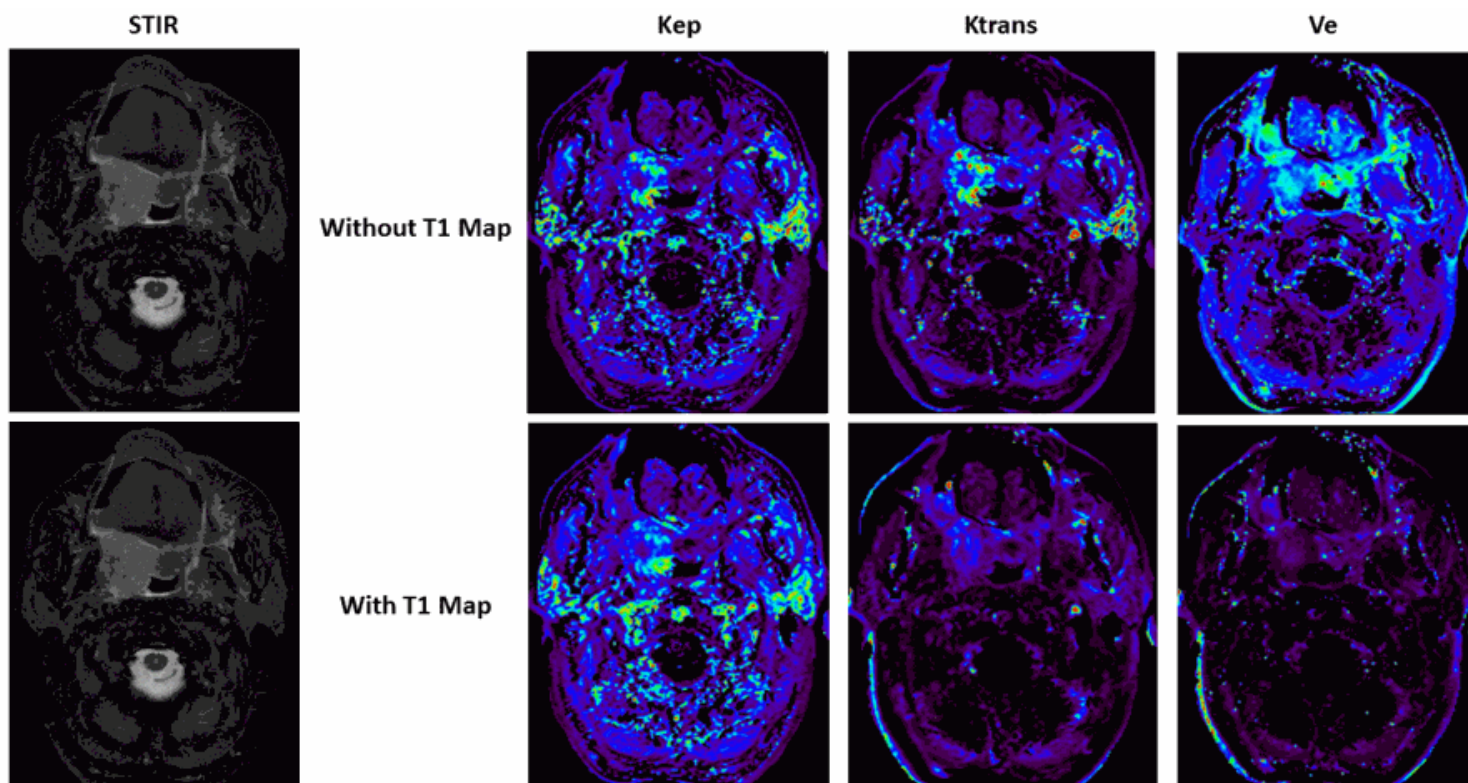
DCE MRI images without T1 mapping demonstrating increased signal and overestimation of kinetic parameters of a right tonsillar SCC compared to images with T1 mapping
